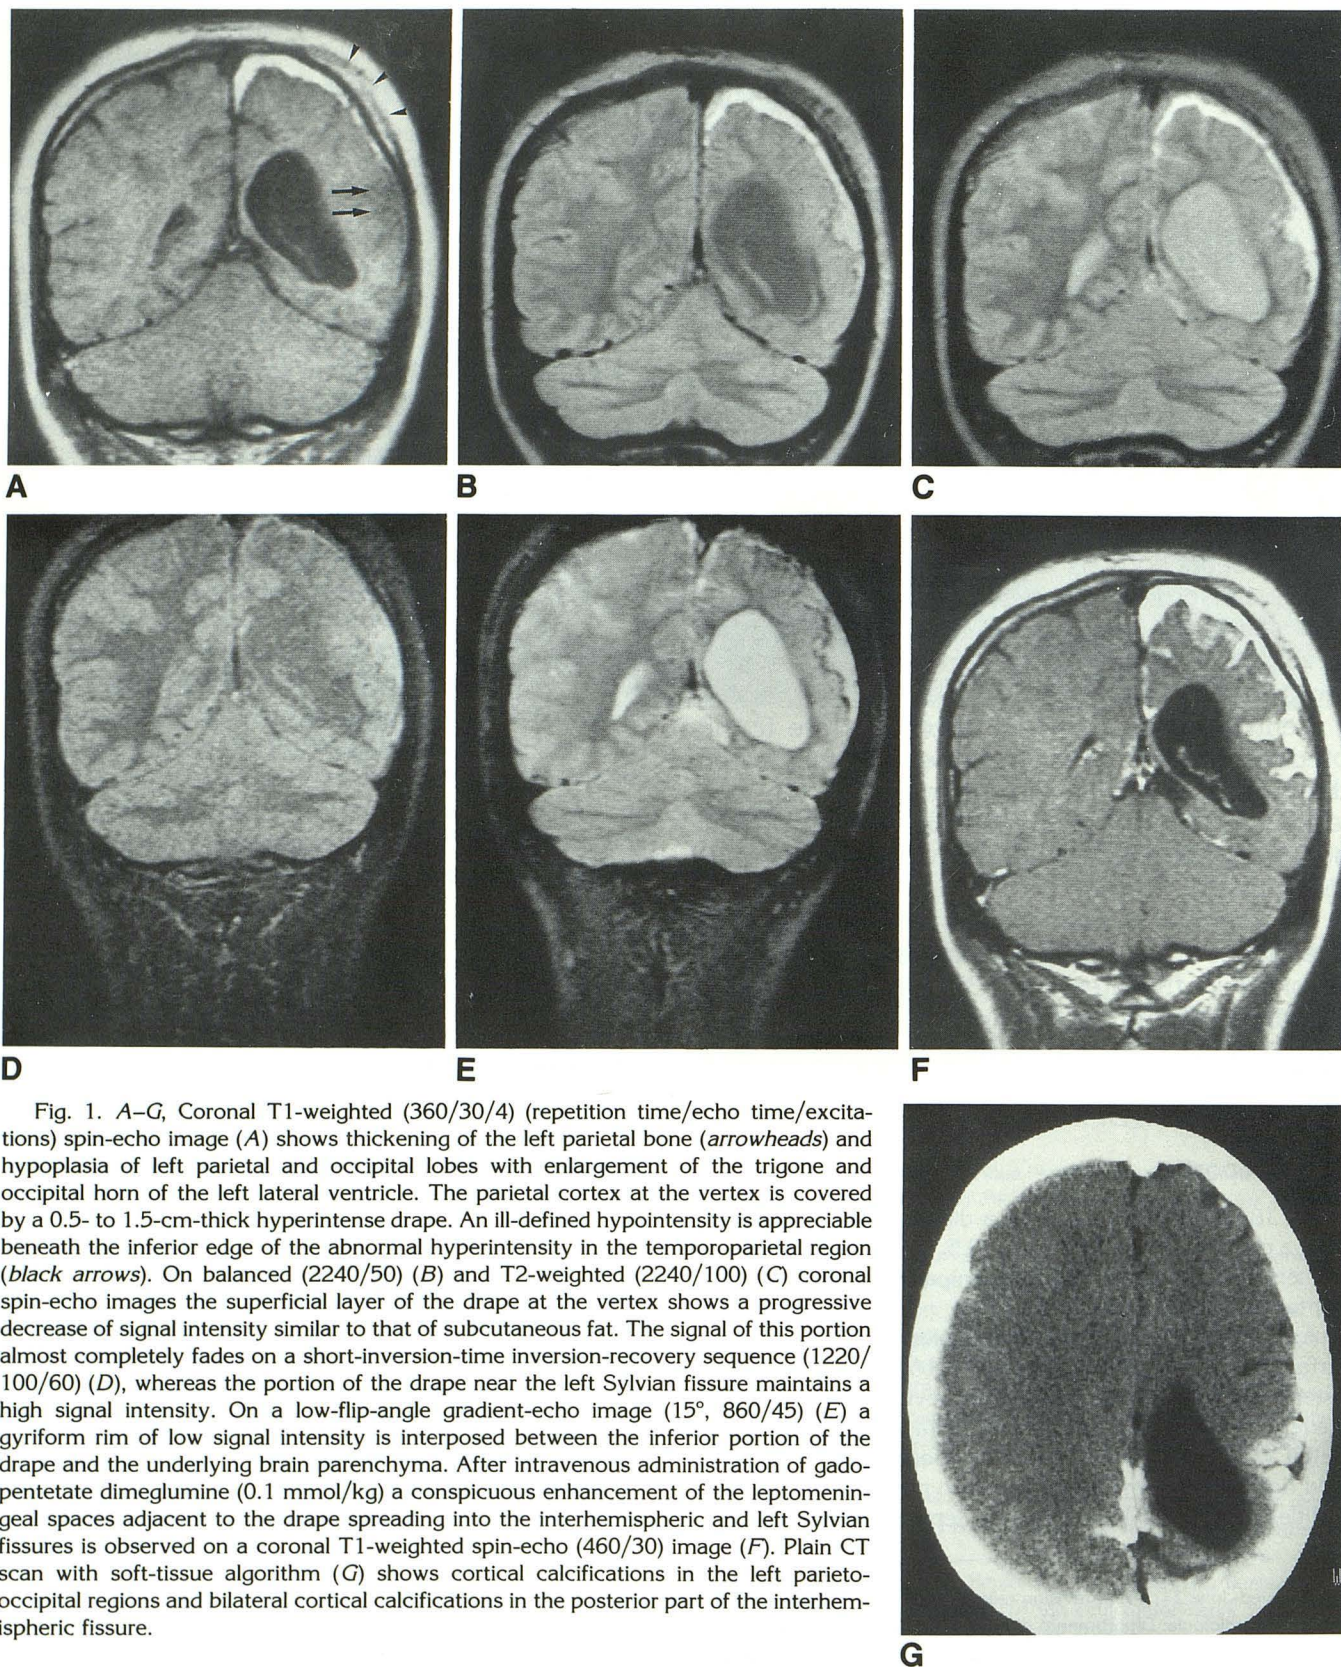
A-G, Coronal T1-weighted (360/30/4) (repetition time/echo time/excitations) spin-echo image (A) shows thickening of the left parietal bone (*arrowheads*) and hypoplasia of left parietal and occipital lobes with enlargement of the trigone and occipital horn of the left lateral ventricle. The parietal cortex at the vertex is covered by a 0.5- to 1.5-cm-thick hyperintense drape. An ill-defined hypointensity is appreciable beneath the inferior edge of the abnormal hyperintensity in the temporoparietal region (*black arrows*). On balanced (2240/50) (B) and T2-weighted (2240/100) (C) coronal spin-echo images the superficial layer of the drape at the vertex shows a progressive decrease of signal intensity similar to that of subcutaneous fat. The signal of this portion almost completely fades on a short-inversion-time inversion-recovery sequence (1220/100/60) (D), whereas the portion of the drape near the left Sylvian fissure maintains a high signal intensity. On a low-flip-angle gradient-echo image (15°, 860/45) (E) a gyriform rim of low signal intensity is interposed between the inferior portion of the drape and the underlying brain parenchyma. After intravenous administration of gadopentetate dimeglumine (0.1 mmol/kg) a conspicuous enhancement of the leptomeningeal spaces adjacent to the drape spreading into the interhemispheric and left Sylvian fissures is observed on a coronal T1-weighted spin-echo (460/30) image (F). Plain CT scan with soft-tissue algorithm (G) shows cortical calcifications in the left parieto-occipital regions and bilateral cortical calcifications in the posterior part of the interhemispheric fissure.
